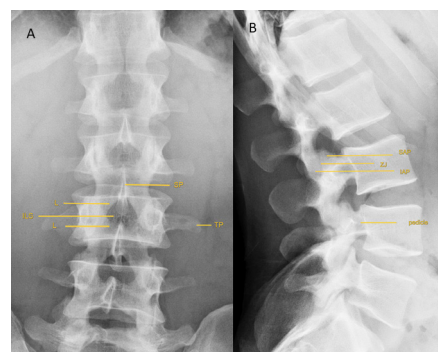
Plain X-ray of lumbar spine. (A) Anterior-posterior view; (B) lateral view. IAP, inferior articular process; ILS, interlaminar space; L, lamina; SAP, superior articular process; SP, spinous process; TP, transverse process; ZJ, zygapophyseal joint.
